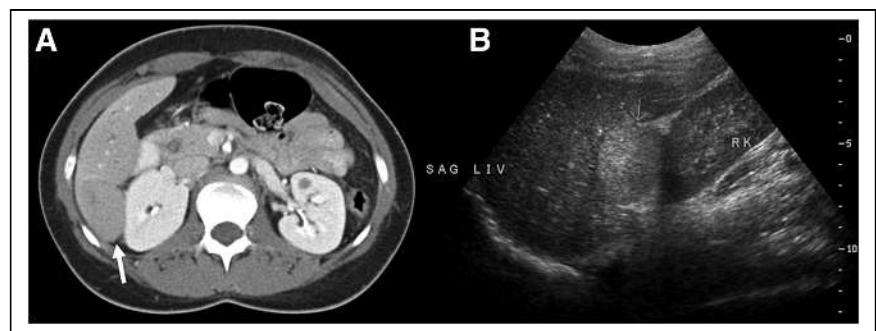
(A) Single-phase CT scan obtained at different hospital does not demonstrate typical arterial enhancement (arrow). (B) Ultrasound image shows hyperechoic mass (arrow). Mass would typically be hypoechoic.
